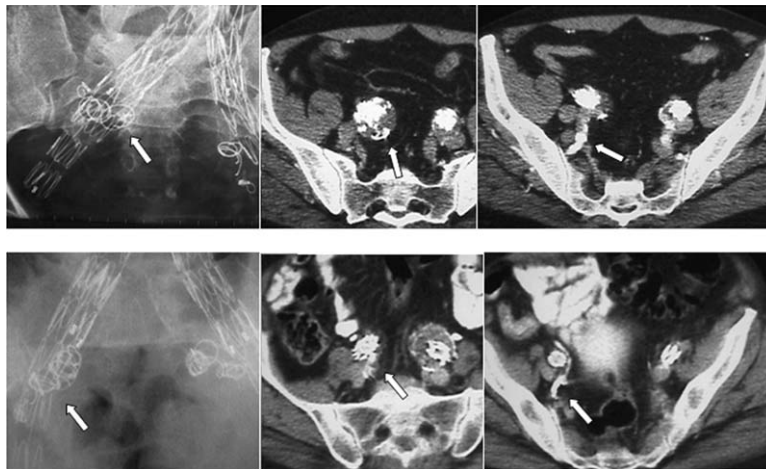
Radiographic and CT controls of two patients treated by selective embolization of the left hypogastric artery before surgery. In a second time, right nonselective hypogastric artery embolization was performed simultaneously with placement of an aortobiliac endoprosthesis. On the left and center images, *arrows* mark the position of the coils. Arrows in left images show occlusion of the hypogastric artery trunk and the patency of pelvic branches.
